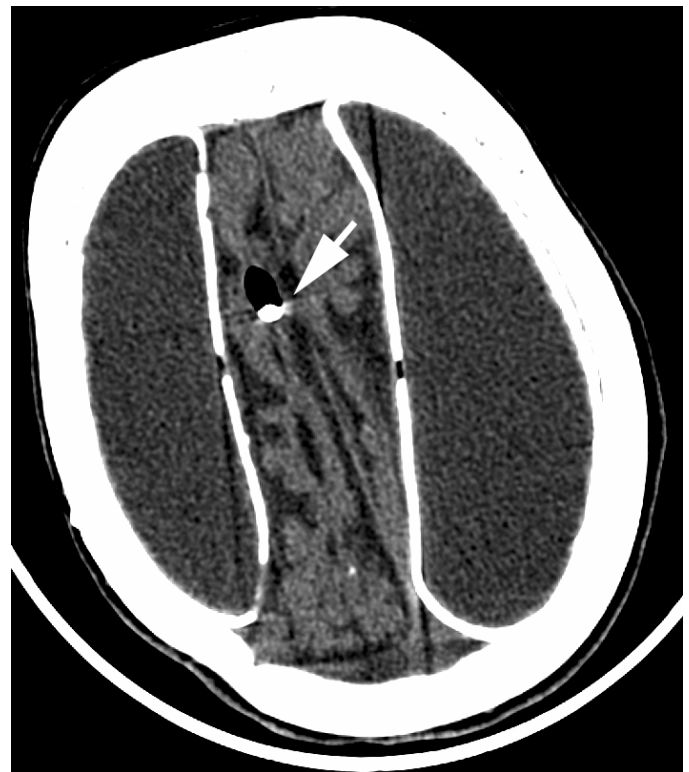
Companion case 4. Noncontrast axial head CT of the brain shows bilateral large, homogeneously low attenuating, extraaxial fluid collections that extend across suture lines but not into the interhemispheric fissure. These findings are consistent with chronic bilateral subdural hematomas, showing marked compression of both lateral ventricles. These subdural collections demonstrate a thin, interrupted rim of dystrophic calcification, which also supports the chronic nature of this process. Note the ventricular shunt (arrow) in place for drainage of hydrocephalus, caused by significant mass effect on the ventricular system.
